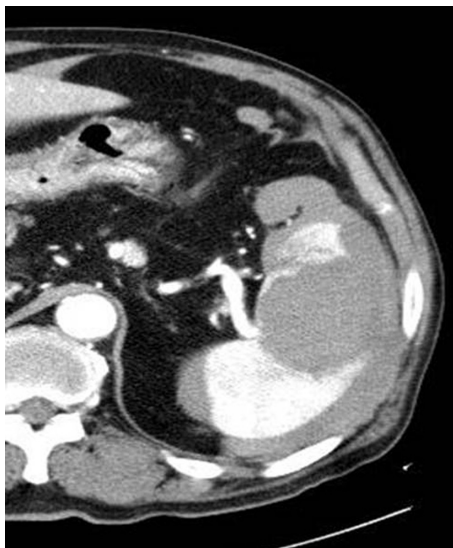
Initial CT scan of 75-year-old man with scrub typhus.
